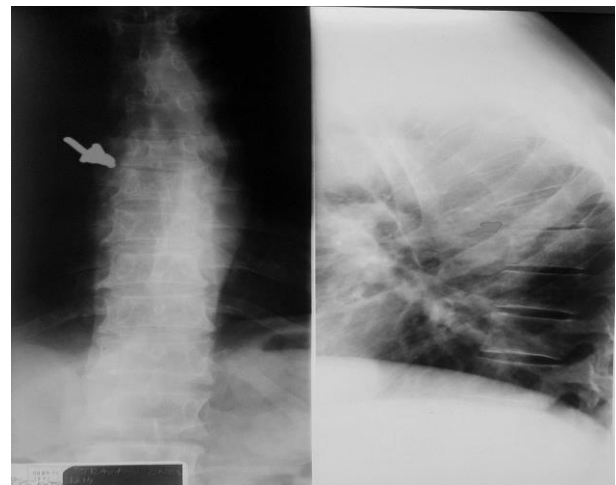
Preoperative thoracic spine radiograph: major narrowing of T7-T8 disc space (personal collection).
